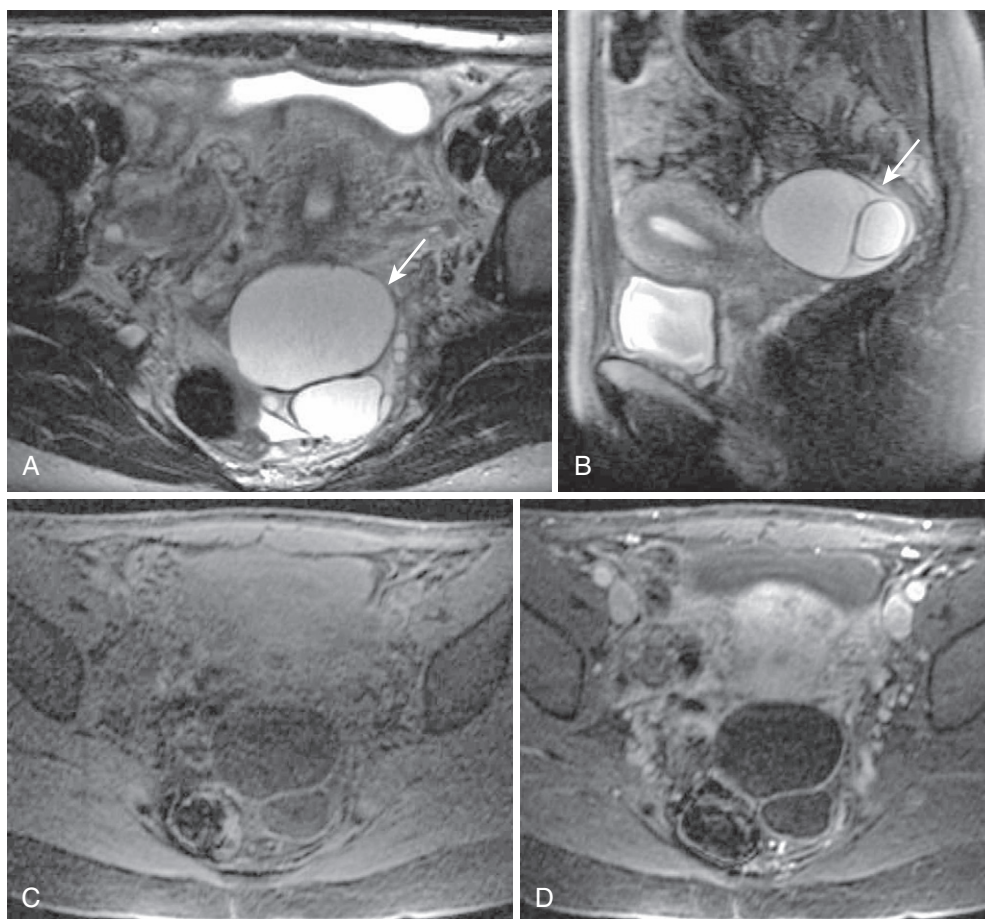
Mucinous cystadenoma. Axial T2-weighted (A) and sagittal fat-suppressed T2-weighted (B) images of a left ovarian mucinous cystadenoma (*arrow*) show multilocularity with thin septation and no other evidence of complexity. Precontrast (C) and postcontrast (D) images confirm the lack of malignant features.
